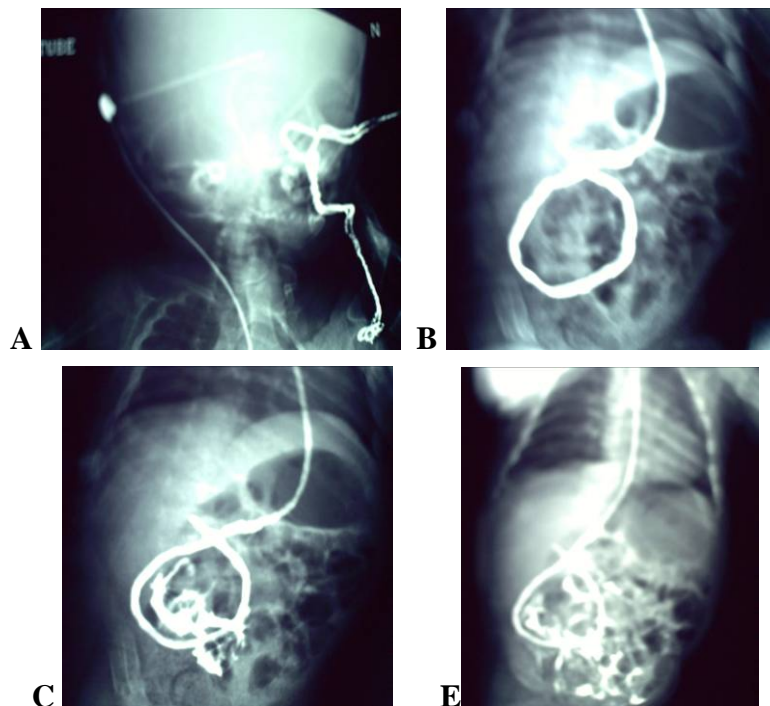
Case 31: female patient 5 M old, CSF was easily aspirated from reservoir but radiographic shuntogram revealed that free peritoneal spilling occurred late after pumping the reservoir denoting malfunctioning valve.
